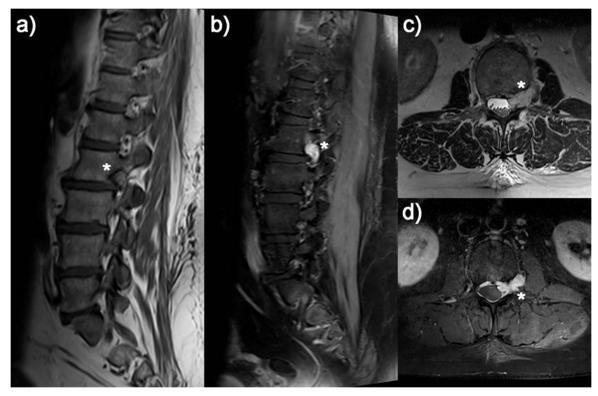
T1-turbo spin echo (TSE), sagittal plane a) showing a nearly isointense intraforaminal lesion at the left neuroforamina of the 2nd and 3rd lumbar vertebra. Transversal T2-weighted TSE c) showing a hyperintense extradural, intra- and extraforaminal lesion around the left nerve root L2. T1-weighted TSE images with contrast enhancement in transversal b) and sagittal d) planes show the hourglass shaped tumor with strong, almost homogenous enhancement.
